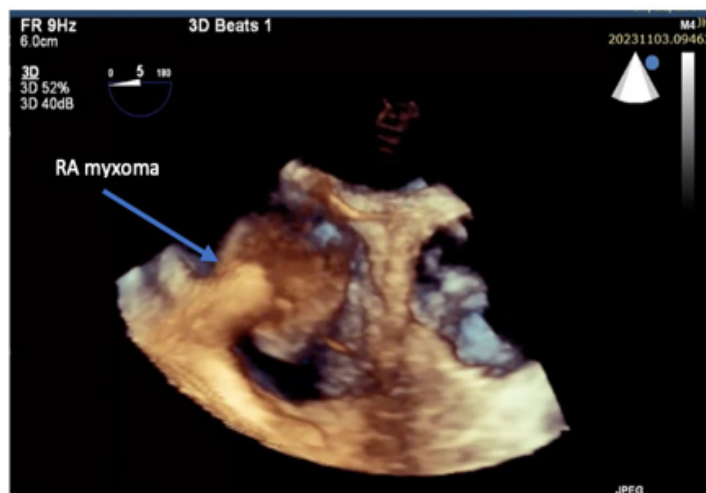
Transesophageal echocardiography 3D reconstruction of right atrial myxoma.
